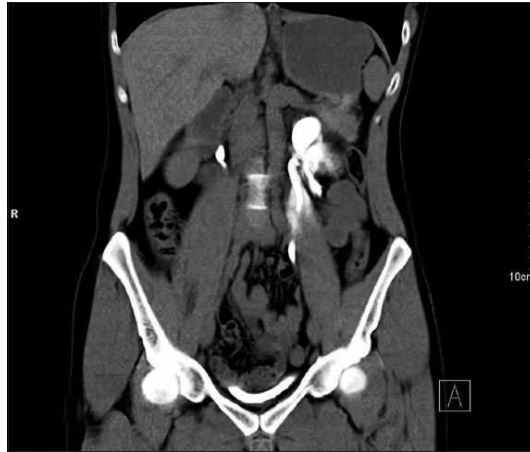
Postcontrast axial CT image shows leakage of radiocontrast media at the level of the upper ureter [27, 28].
